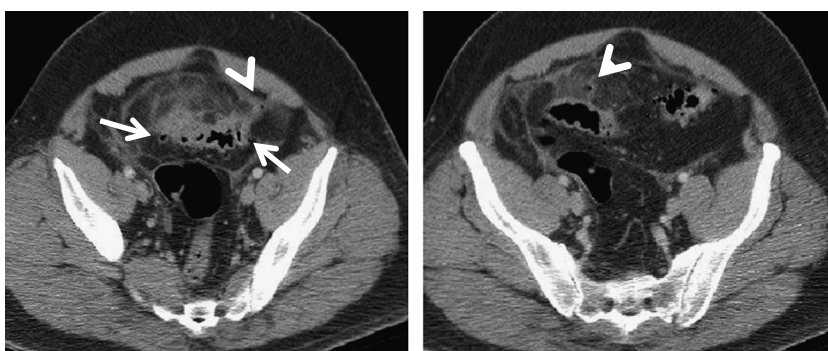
Perforated sigmoid diverticulitis in a 55-year-old man. Axial contrast CT images of the pelvis show diverticulitis of the sigmoid colon (arrows) with small air pockets surrounding the colon (arrowheads) suggestive of perforation.
